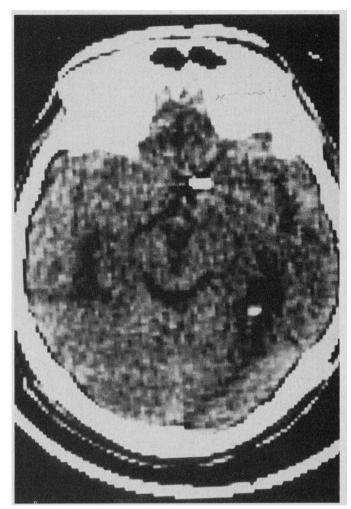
Case 2. Computed tomographic scan showing catheter tip in septal area.
